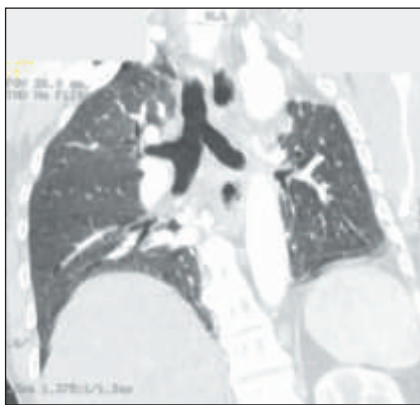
CT thorax bronchus view
